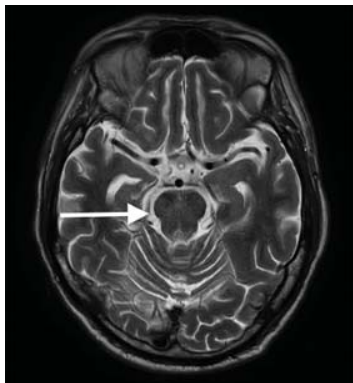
Axial T2-weighted magnetic resonance imaging repeated several months after presentation showed an improved lesion in the pons (arrow).
